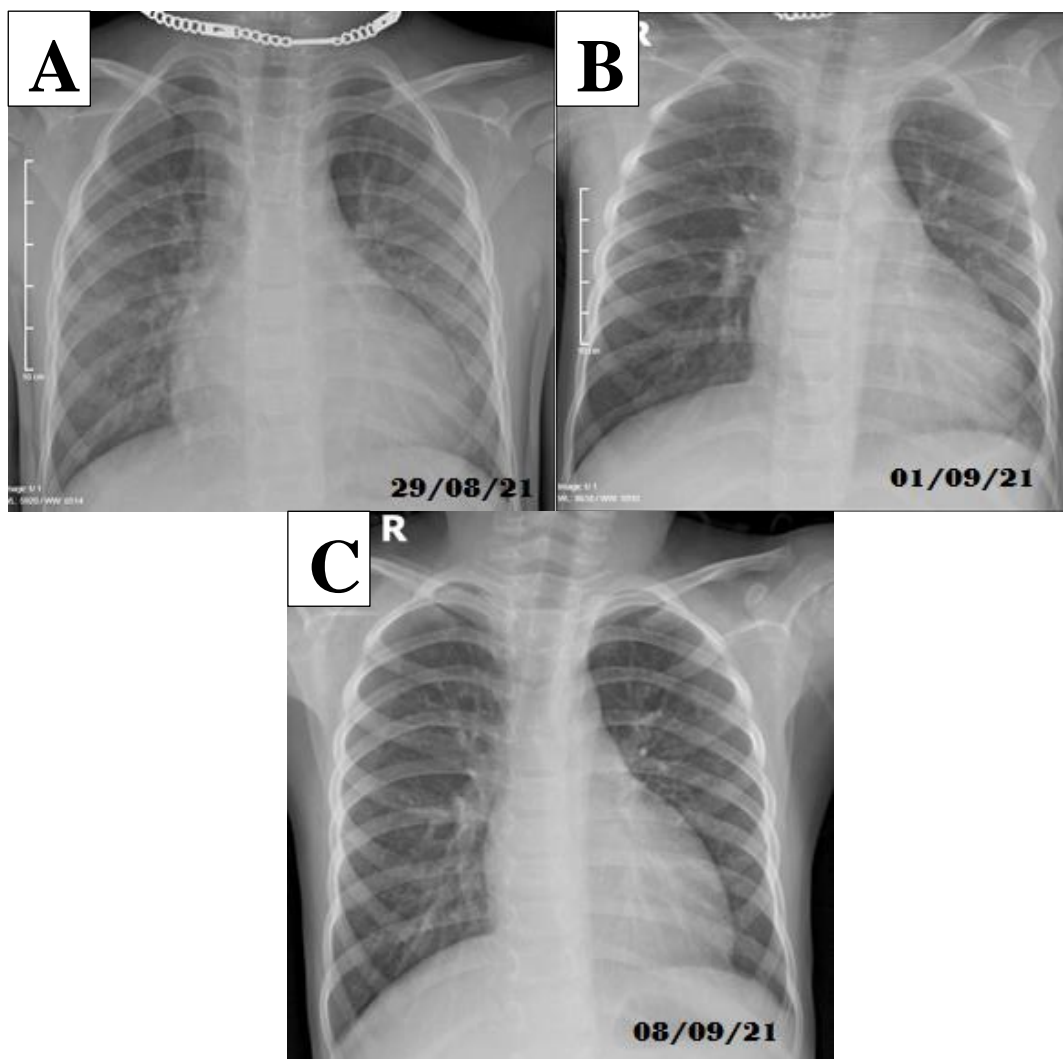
Pulmonary radiography progression. A) Heterogeneous opacities on both sides of the lungs with enlarged heart. B) After 2 days of anti-inflammatory treatment, the cardiothoracic index decreased. C) Normal chest x-ray
